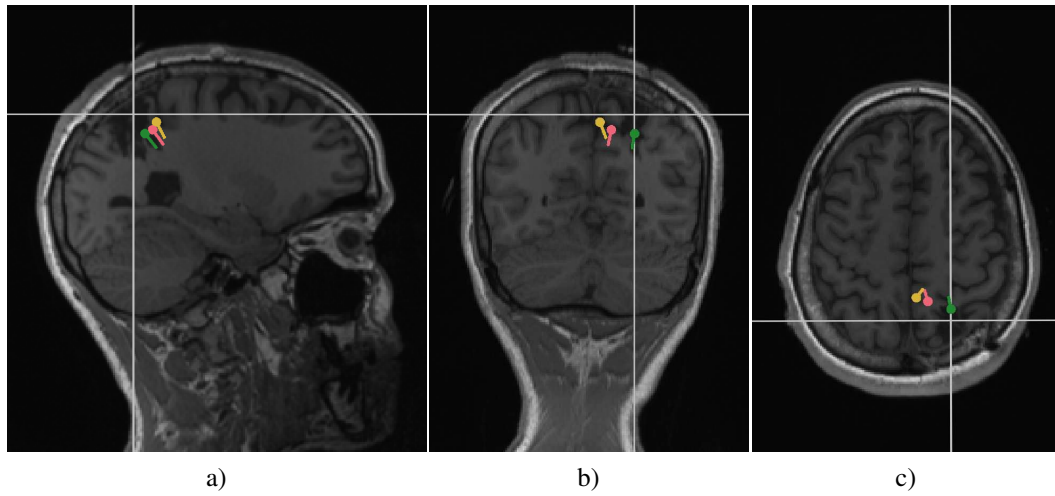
Single dipole deviation scan results for EEG (green), MEG (yellow) or combined EEG/MEG (red) superimposed on the post-surgical T1-MRI (not in radiological convention): a) sagittal, b) coronal and c) axial planes through the resected area, the slices used for the visualization are marked by gray lines.
